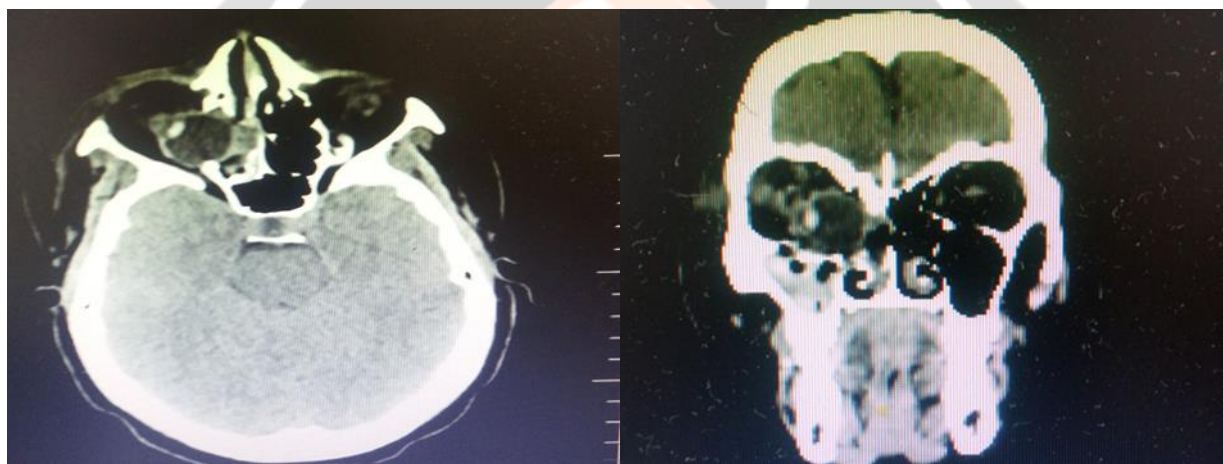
a) Axial CT scan showing right medial wall fracture with globe in the ethmoid sinus b) Coronal CT scan showing floor and medial wall fracture with right maxillary sinus effusion and dislocated right globe into the orbit
